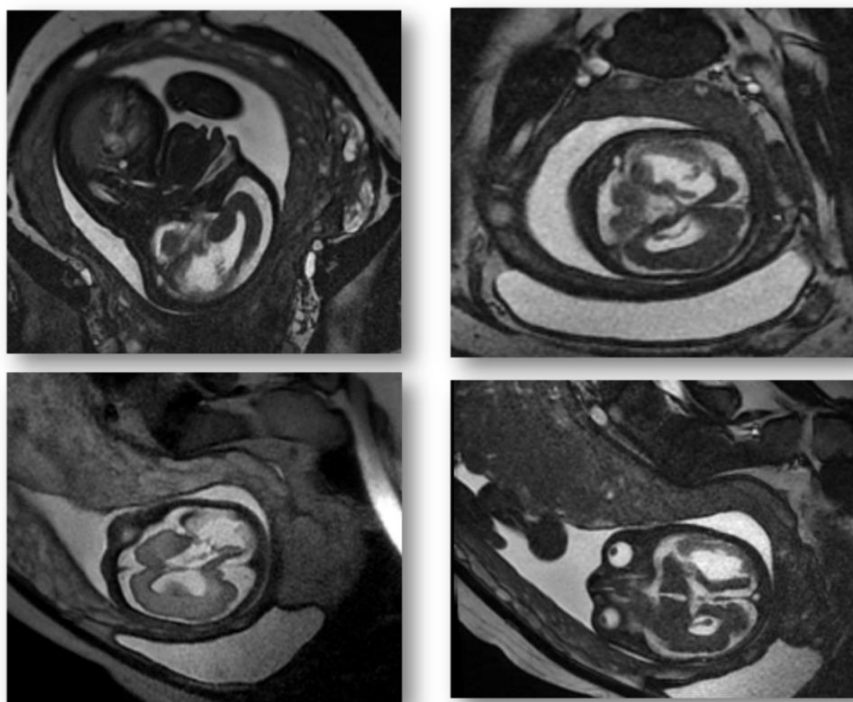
Fetal MRI shows moderate ventriculomegaly with bilateral destructive lesions and abnormal gyration
